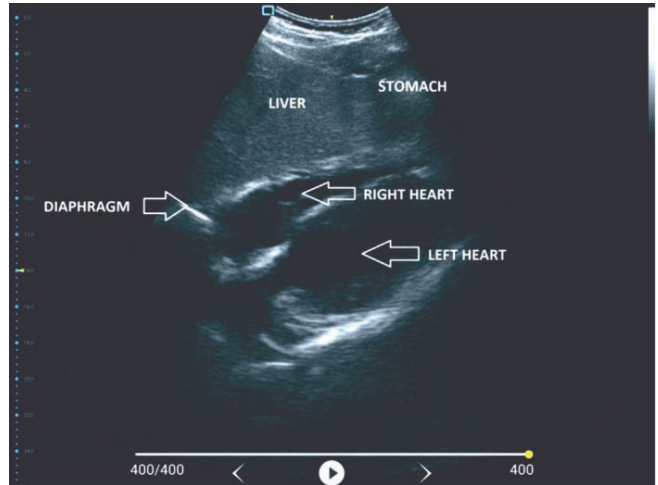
Ultrasound image from subcostal projection
